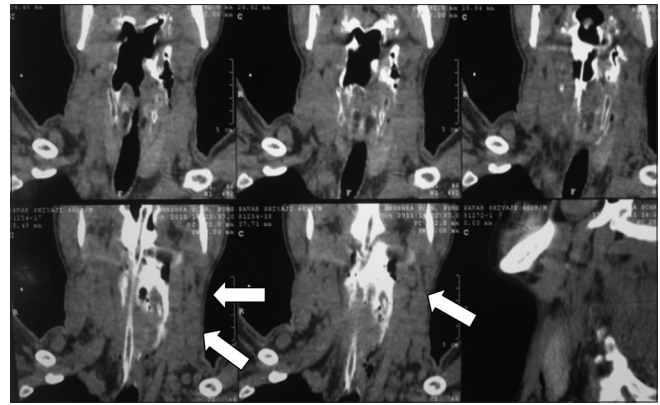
CT Scan of neck showing leak along lateral wall of left pyriform sinus with visualization of contrast along lateral wall of pharynx, cervical esophagus and retropharyngeal space (marked by arrows)
